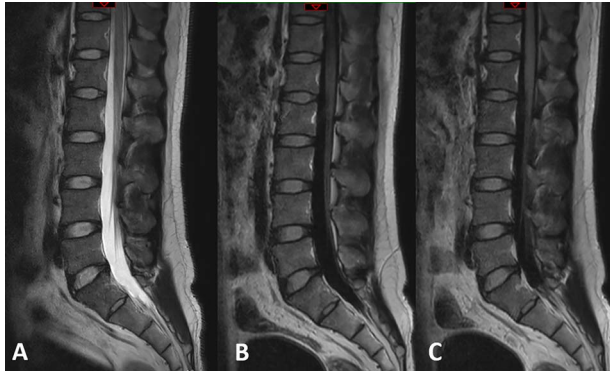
Spinal MRI without enhancement conducted on the fourth day of admission. (A) Sagittal T2WI, (B) T1WI and (C) fluid-attenuated inversion recovery image did not reveal any lesions in the spinal cord.
